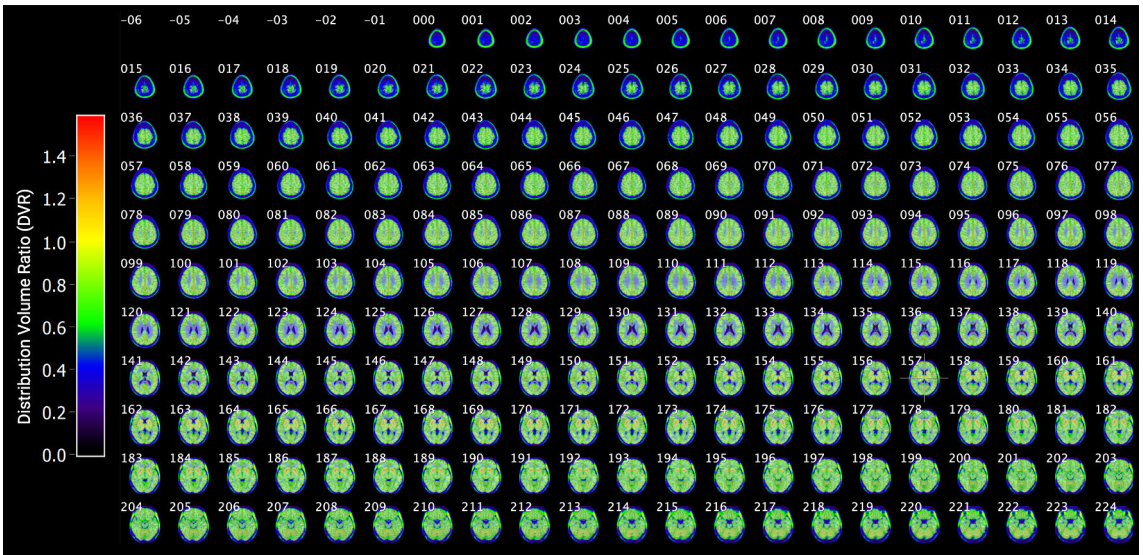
Average PET image from healthy participants, overlaid on CHBET T1 MRI anatomical template, acquired with the A_{2A} receptor specific radiotracer [^{11}C]TMSX. The axial parametric image shows the expected distribution of A_{2A} receptors, with highest binding in the striatum, particularly the putamen and caudate, while cortical regions exhibit lower uptake.
